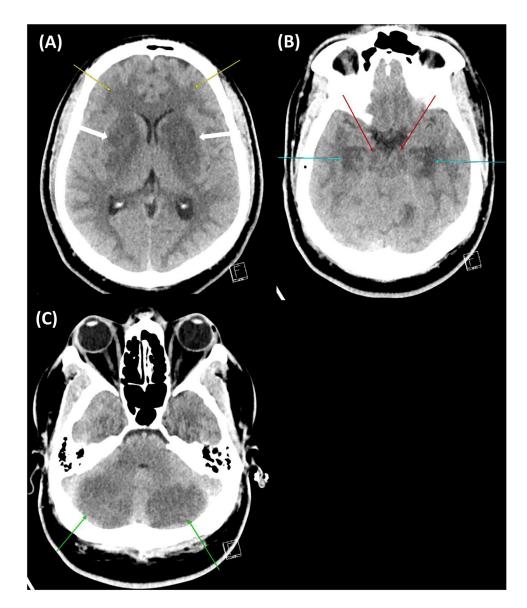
CT Head Axial images at the level of the lateral ventricles (A) and cerebral peduncles (B) and cerebellum (C) demonstrate hypodensity of the deep and subcortical white matter (yellow arrows), basal ganglia (white arrows), cerebral peduncles (red arrows), hippocampi (cyan arrows), and cerebellar hemispheres (green arrows).
